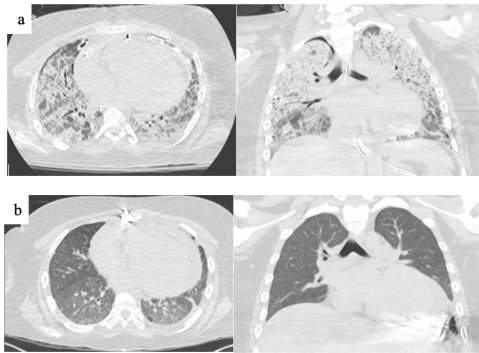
a) Computed tomography (CT) of chest showing significant bilateral ground glass opacities postoperatively from LVAD placement. b) CT of chest prior to heart transplantation one month later showing marked improvement in aeration of both lungs with residual bibasilar ground glass opacities.
